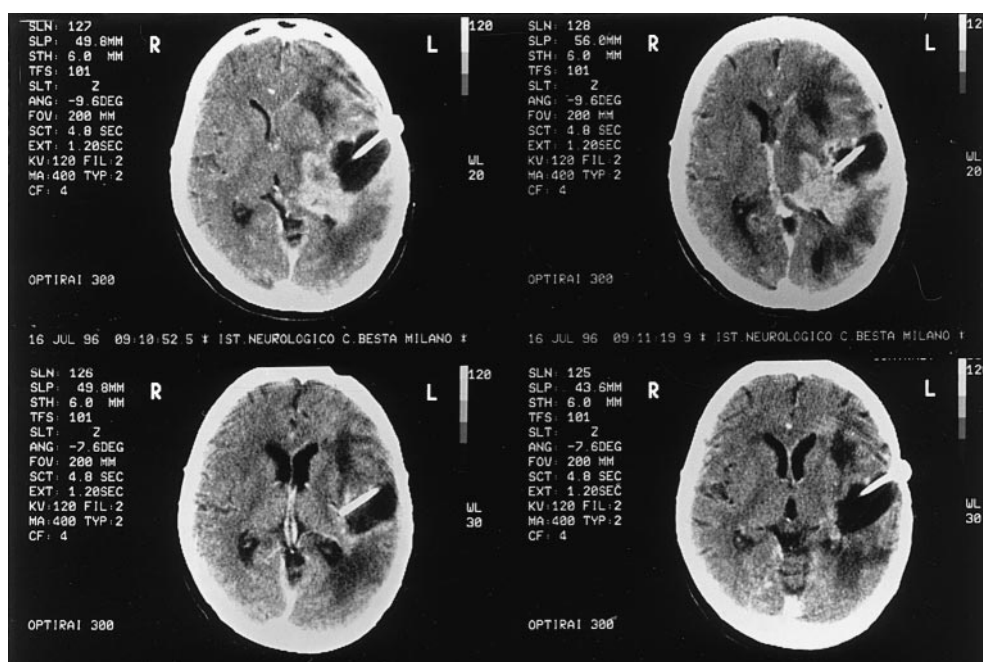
CT scan of a partially responding patient with previously progressing GBM. An improvement in the KPS score concomitant with tumor shrinkage persisted for 5 months
